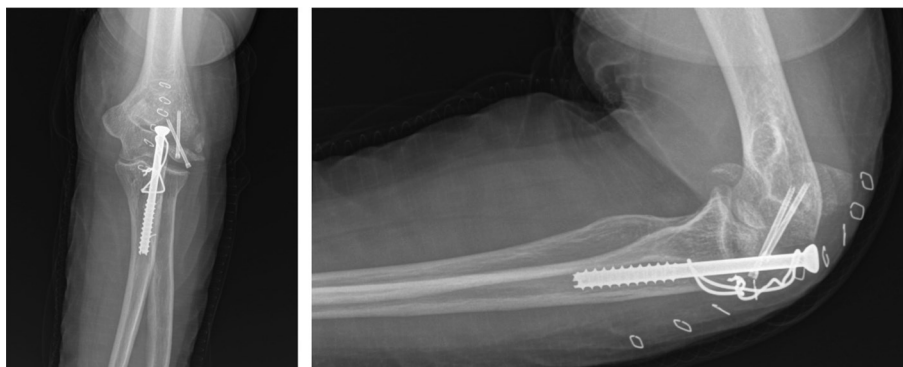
AP and lateral view of radiographs showing osteonecrosis of the capitellum after initial osteosynthesis.
